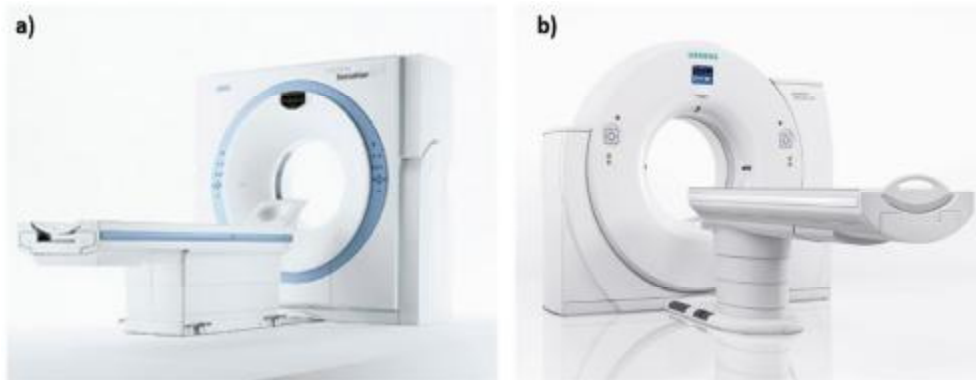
a. Siemens Somatom Sensation 64, b. Siemens Somatom Definition AS CT scanners (web4, 2018)
